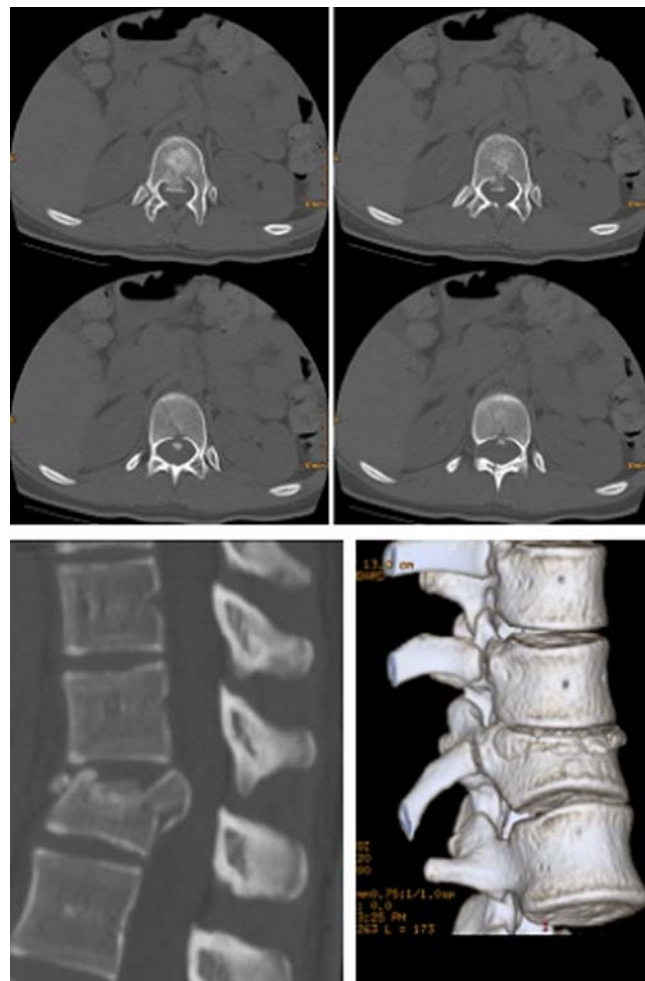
Transversal CT layer and two-dimensional and three-dimensional reconstruction of the injury
